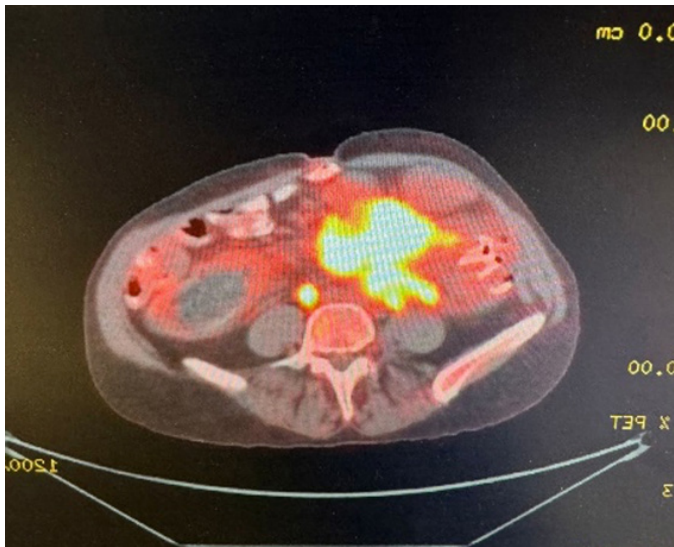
Mass appearance on CT (horizontal section)
